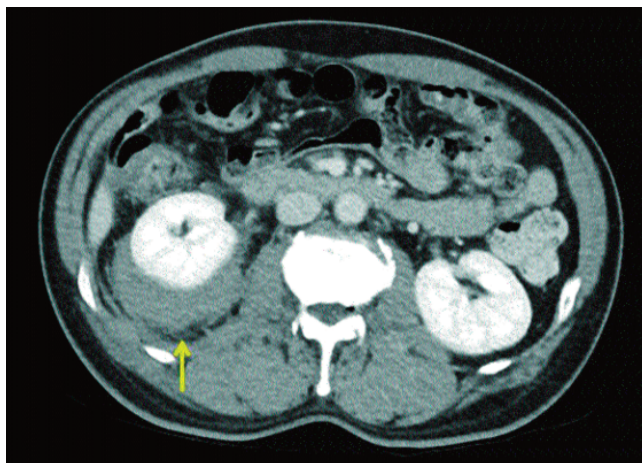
Follow-up computed tomography (CT) scan of the abdomen. Right-sided perirenal haemorrhage was detected (Arrow).
